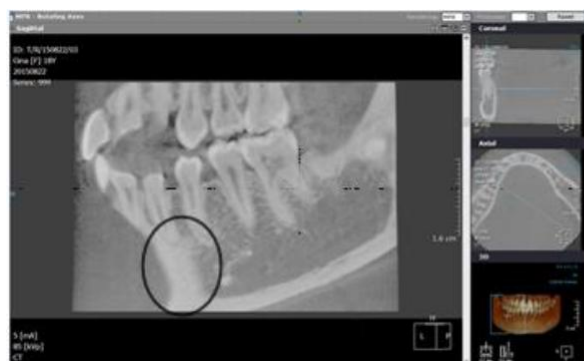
CBCT image of mild cortical bone loss.
